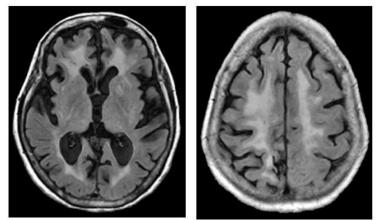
FLAIR axials: white matter hyperintensities in bilateral periventircular regions and centrum semiovale
